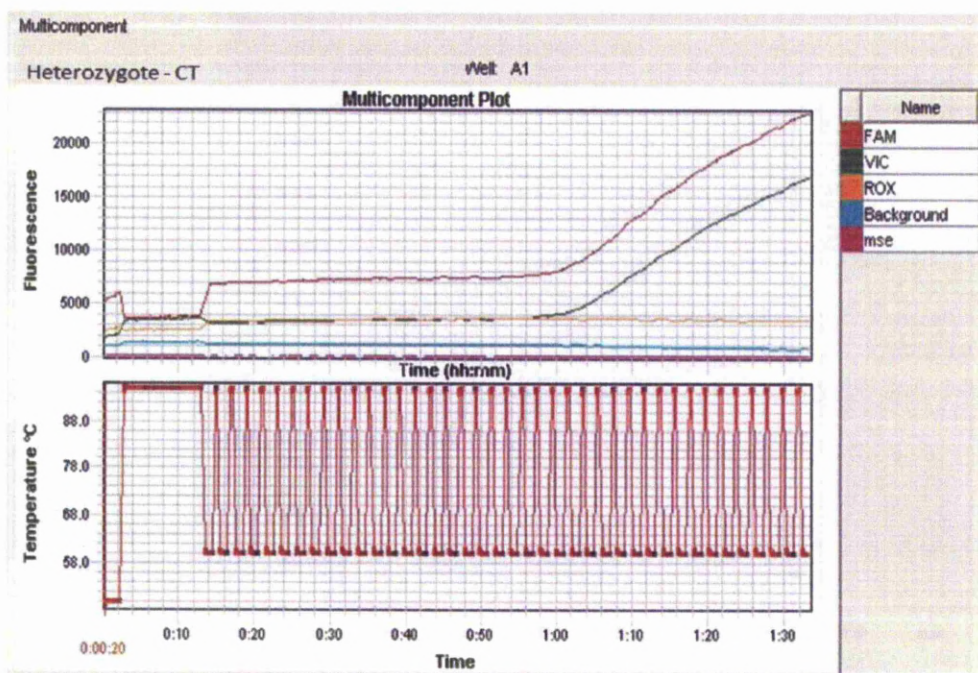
LXR $\alpha$  SNP rs2279238C/T: Representative Plot of Heterozygous-CT by allelic discrimination assay by qPCR, n=1
